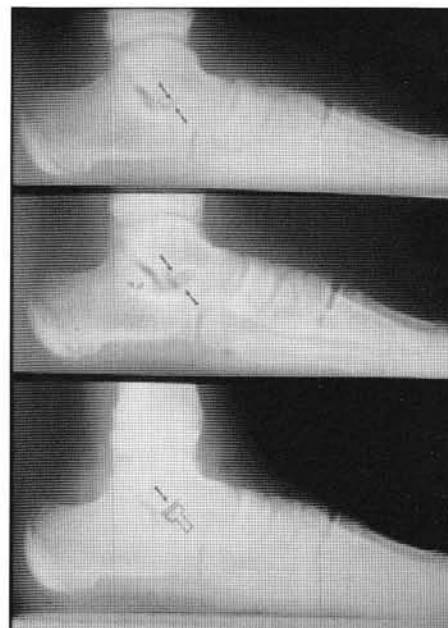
Lateral Radiographs. 1. Relaxed stance position preoperatively. 2. Neutral stance position preoperatively. 3. Relaxed stance position with STA-peg implant in place.
